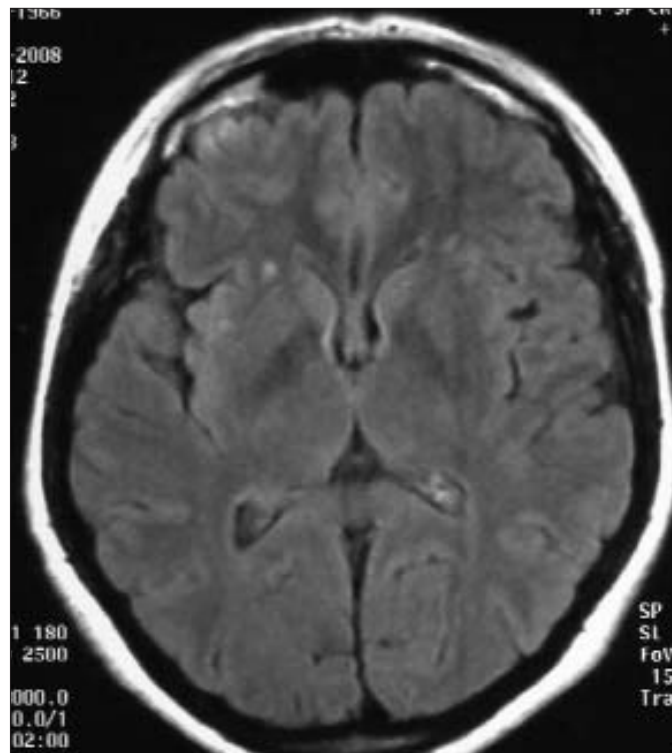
Cranial MRI study of the index case's sister-in-law. Axial FLAIR sequences
